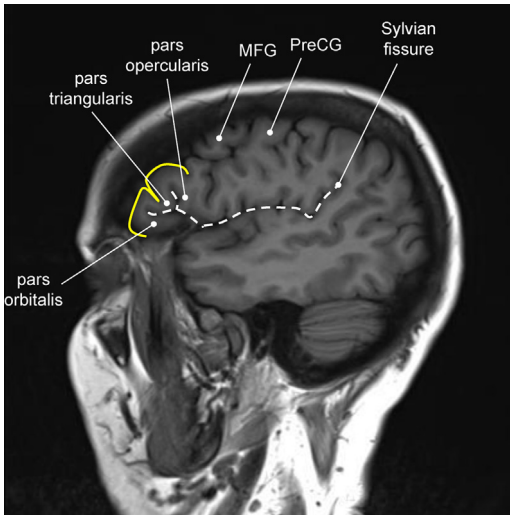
Far lateral sagittal T1-weighted image at the level of the Sylvian fissure and frontal operculum. Labeled gyri include the yellow M-shaped inferior frontal gyrus, consisting of the pars orbitalis, pars triangularis, and pars opercularis; middle frontal gyrus (MFG), and precentral gyrus (PreCG). The Sylvian fissure courses horizontally across the image as denoted by the dashed line, with its anterior and ascending rami separating the pars orbitalis, pars triangularis, and pars opercularis of the inferior frontal gyrus, respectively.
